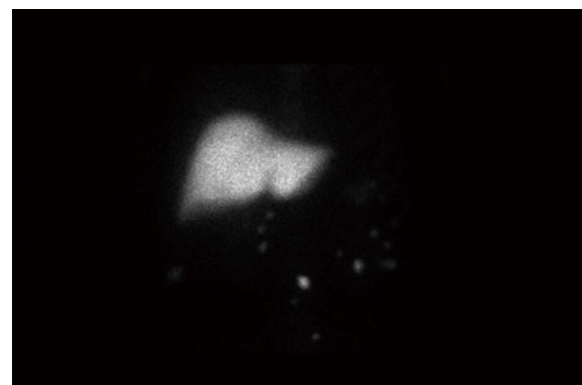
Nuclear scintigraphy image of this patient demonstrating uptake in the ectopic tissue seen in the pelvis and beneath the liver on the computed tomography images, confirming they are ectopic splenic tissue. Liver shows normal tracer uptake.
